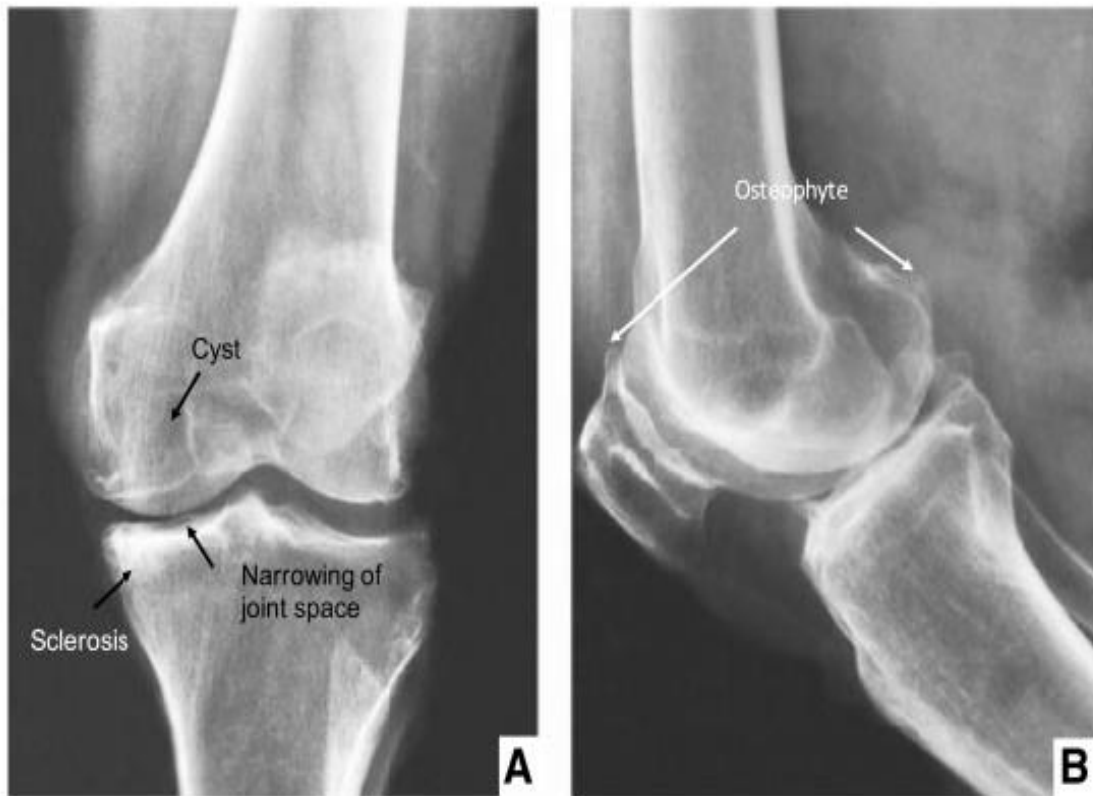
Radiographic features of OA knee
